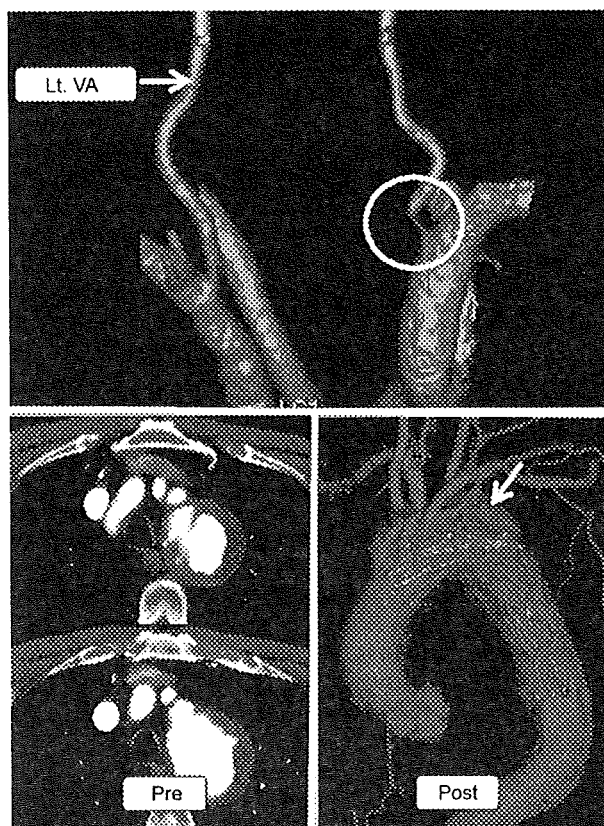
CTA and CT images. CTA of the vertebral artery revealed stenotic orifice (white circle) of right VA (upper). A fenestrated stent graft well preserved antegrade blood flow into LSA as well as LCC (lower). Postoperative CTA shows complete thrombo-occlusion of distal aortic arch aneurysm (lower, white arrow). Lt. VA, left vertebral artery.
